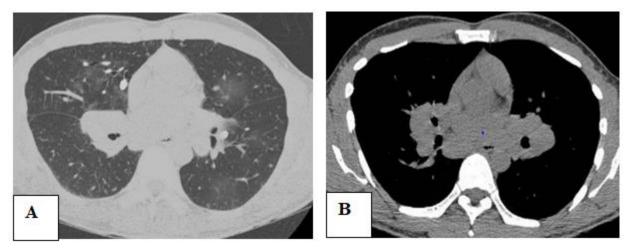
29-years old female patient, with a history of dyspnea and cough referred for CT guided biopsy from enlarged bilateral hilar and mediastinal lymph nodes with imaging features suggesting pulmonary sarcoidosis. (A) and (B) axial CT chest imaging with lung and mediastinal window respectively showed bilateral pulmonary ground-glass opacities worrisome of interstitial pneumonitis versus viral pneumonia (CORADS 3). RT-PCR was positive for
